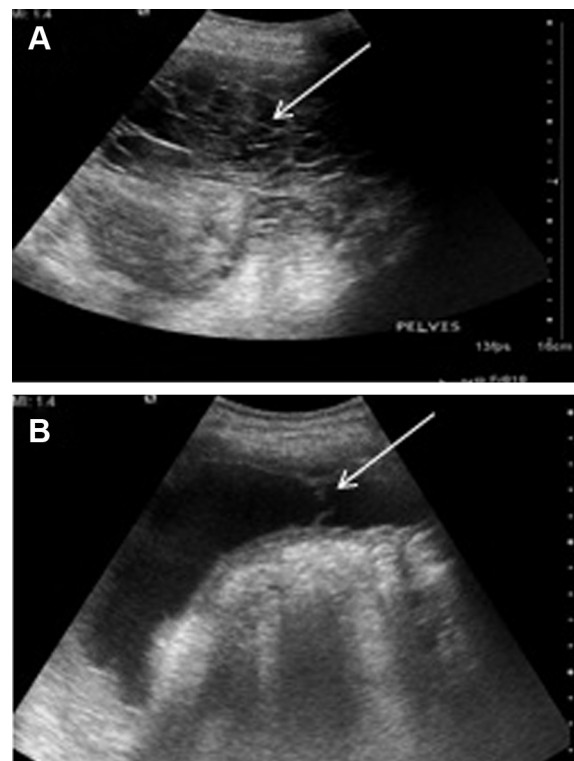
(A) Transverse ultrasound image of the pelvis showing a honeycomb appearance (white arrow) indicating densely loculated ascites. (B) Transverse ultrasound image of the pelvis on the second day of fibrinolysis showing markedly reduced loculation with some residual fibrin stranding in the midline (white arrow).
